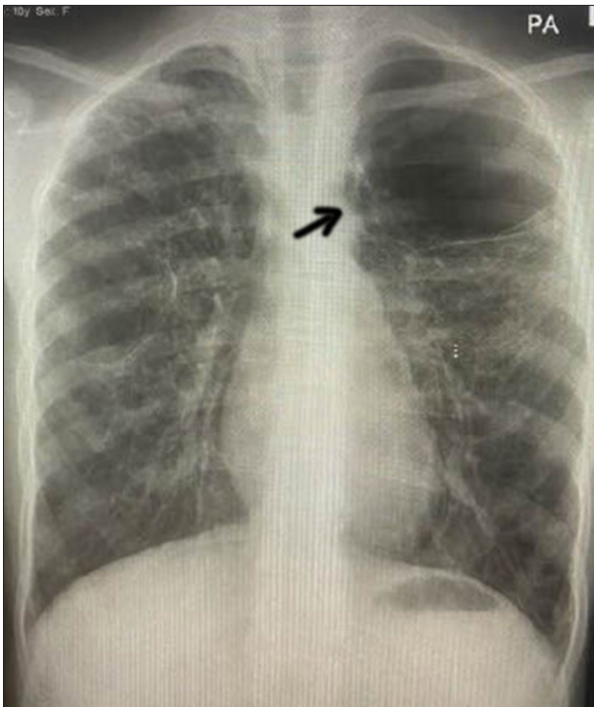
Chest X-ray with marked hyperinflation and marked radiolucency in the left upper zone, with no vascular vessels suggestive of a localized cyst (black arrow). Furthermore, multiple cavitations in the right upper and middle zones were observed.
